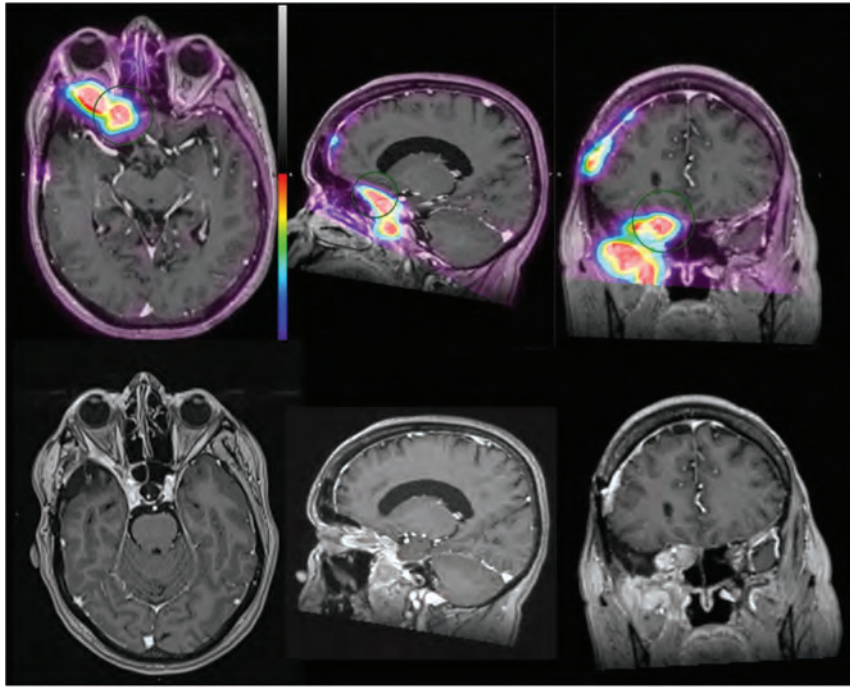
A 63-year-old woman post-right pterional craniotomy for meningioma resection with SSTR-avid recurrent meningioma arising from the right sphenoid wing and infiltrating the right orbital apex, right cavernous sinus, right sphenoid sinus, and right posterior ethmoid air cells and extending inferiorly along the right anterior temporal convexity and into the right masticator space. SSTR-positive recurrence is also noted at the right frontal craniotomy site. In this example, SSTR-PET/MRI findings were more extensive than on the basis of structural imaging because the extracranial tumor component was not identified on contrast-enhanced MR imaging.
